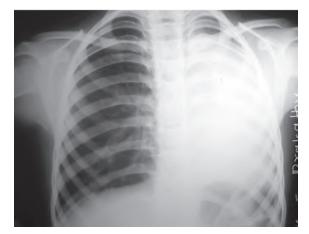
Chest radiograph: Collapse of entire left lung
